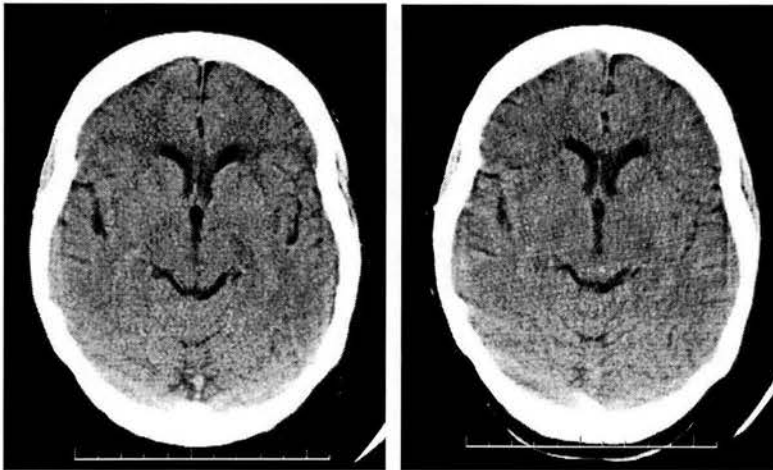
A patient with a total anterior circulation syndrome (TACS) with two normal CT scans
